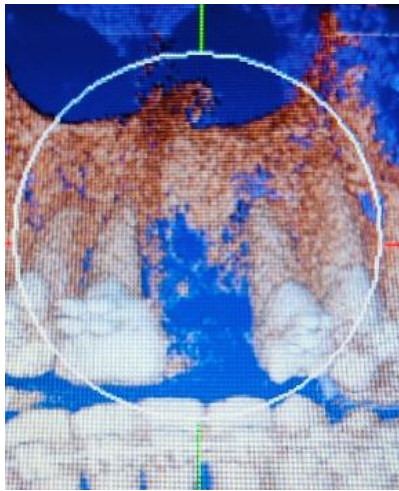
CBCT of 21 region.
